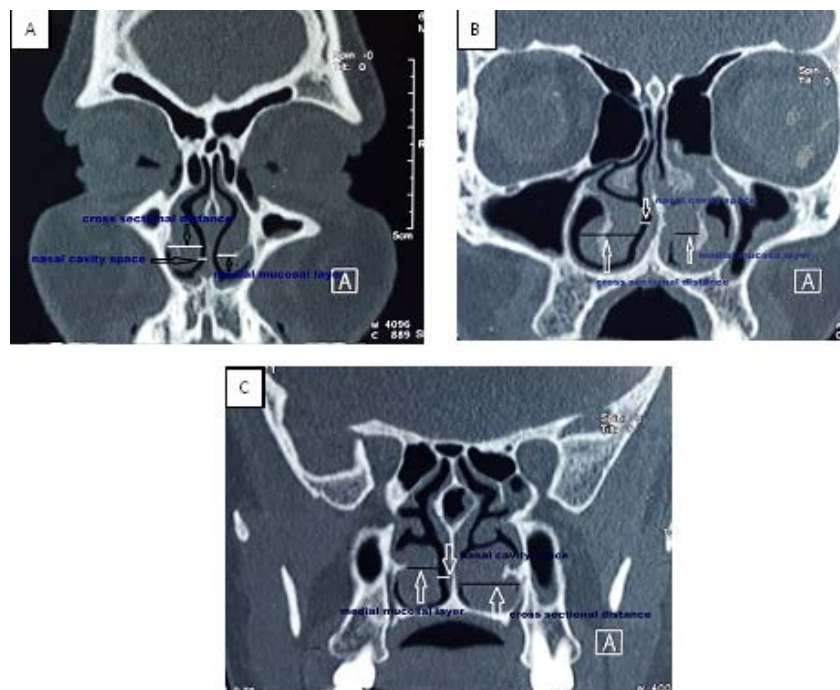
Preoperative inferior turbinate bone-window parasinaxial sinus coronal computed tomography showing lines for measuring nasal cavity, medial mucosal layer, and cross-sectional inferior turbinate distances. (A) Level 1. (B) Level 2: maxillary sinus ostium/uncinate process. (C) Level 3: largest posterior inferior turbinate-end.
